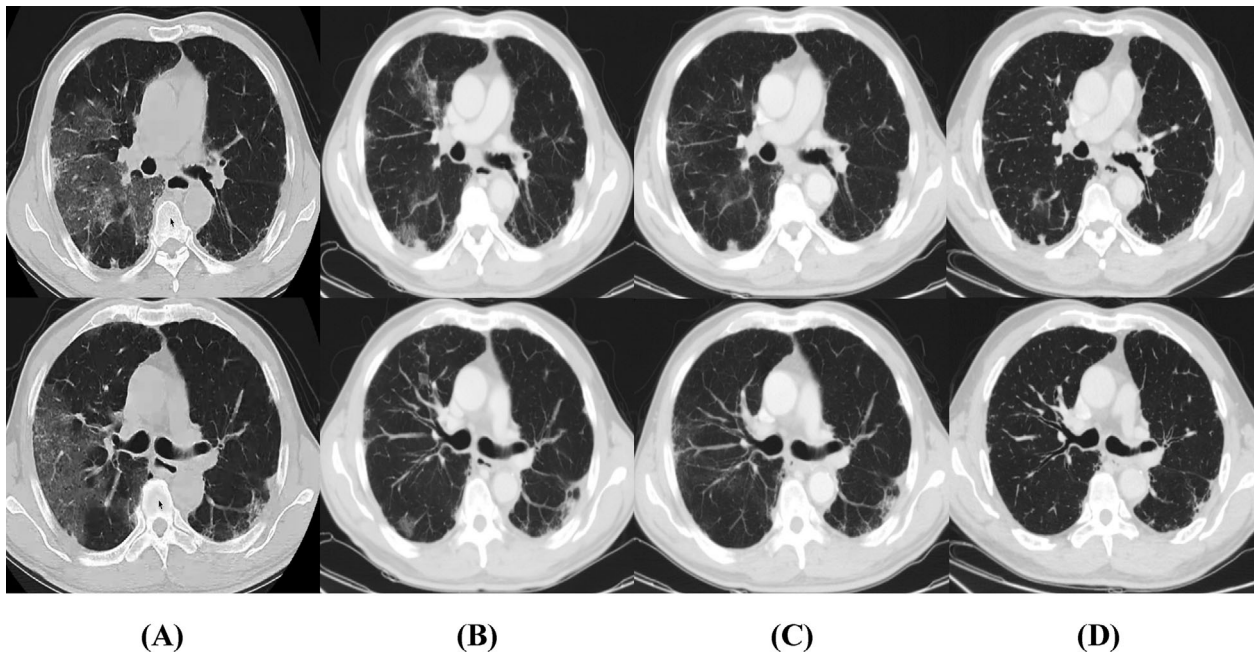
COVID-19 pneumonia was evaluated based on the chest CT scans. (A) Bilateral pneumonia with a CT-SS score of 15/25 at the time of COVID-19 disease. (B) One month later, chest CT showed improvement of pulmonary injury. (C) After completion of 35 cycles, chest CT revealed a partial response. (D) One year after completing treatment, his disease has remained stable throughout the treatment-free follow-up.
